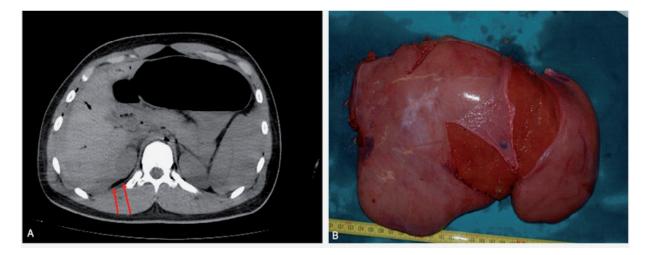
A) Axial computed tomography (CT) scans: irregular hepatic shape (red arrows) with uneven structure for hepatic rupture consequent a car accident. B) Autopsy photograph: view of the liver lacerations.
